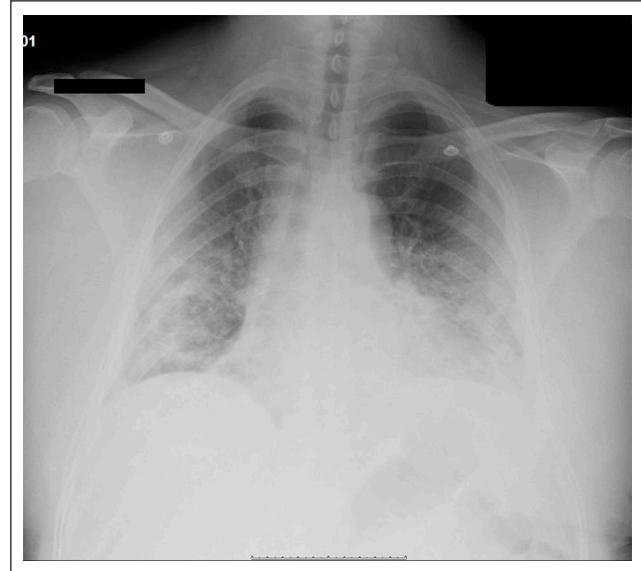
AP chest X-ray, 47-year-old male, diffuse bilateral multi-lobar opacities.
